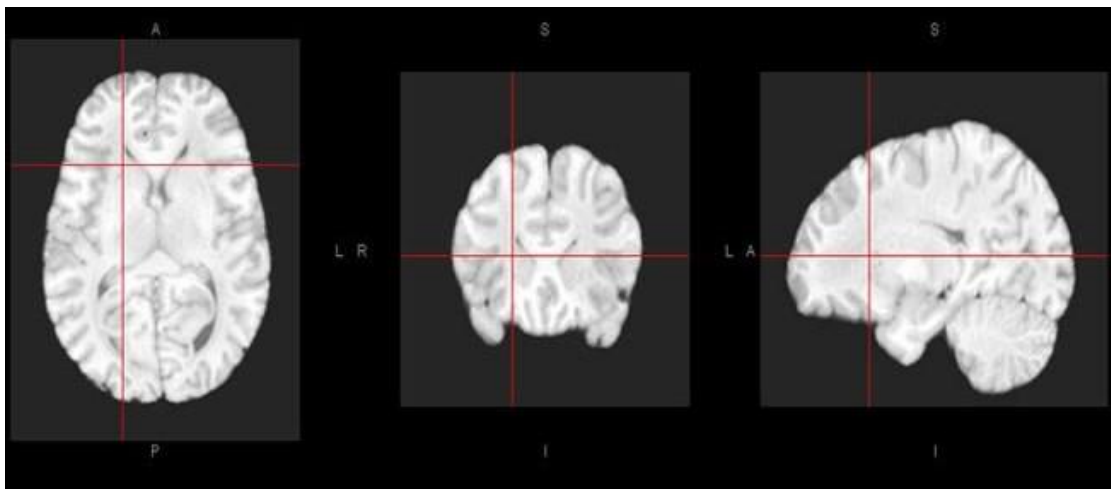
Three types of views of brain MRI with mapping.
